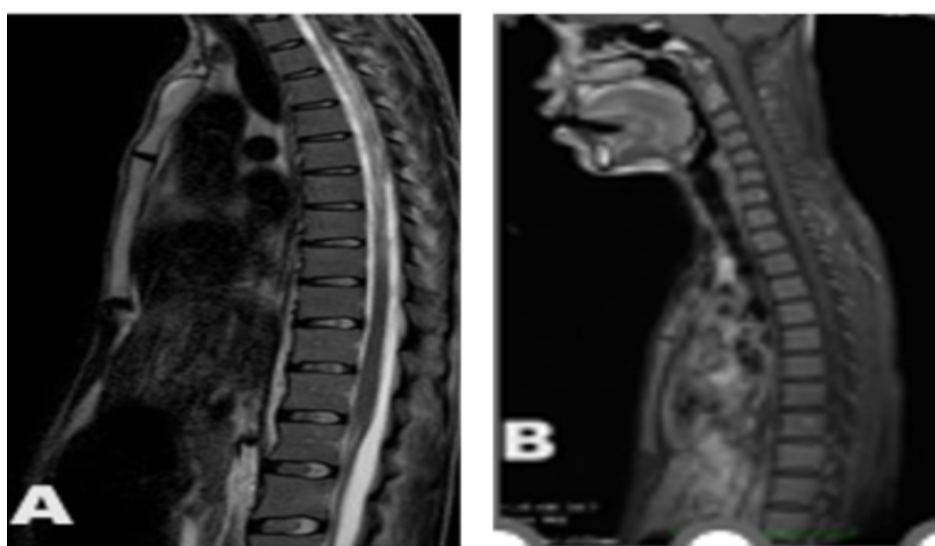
MRI spine sagittal views showing altered signal intensity and heterogeneous enhancement extending from C7 to D5 levels
